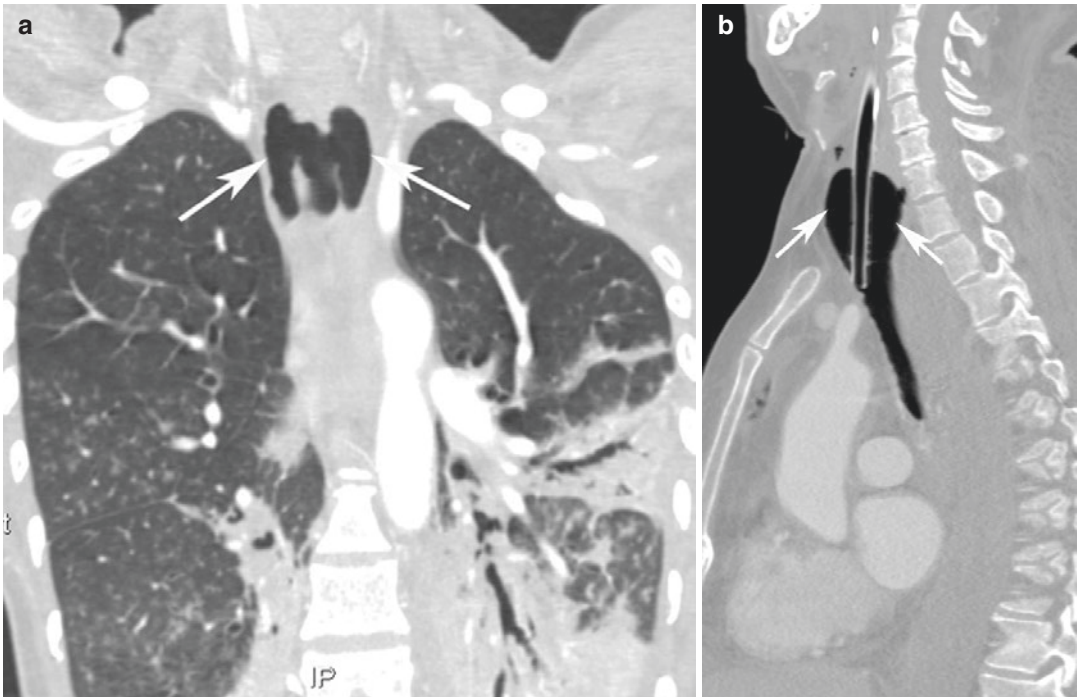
CT coronal (a) and sagittal (b) reconstruction evidence the over-distension of the tracheal tube balloon, herniating through injury site
